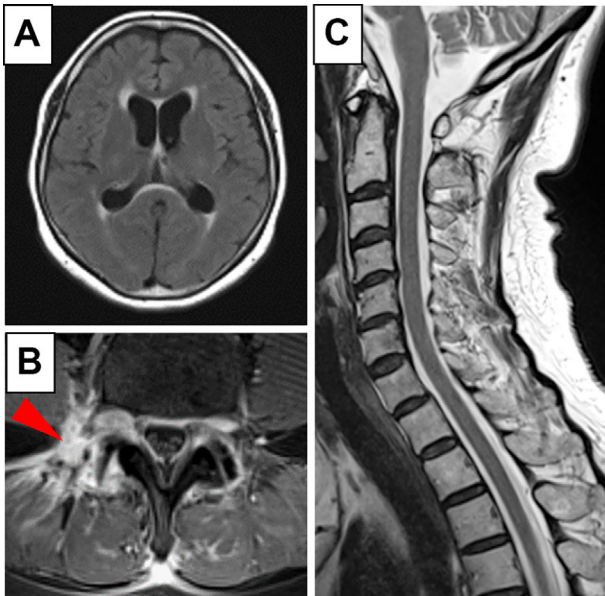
Magnetic resonance imaging, also showing cerebral periventricular hyperintensity on a fluid attenuated inversion recovery image (A), and abnormal lumbar nerve root gadolinium enhancement (B, arrowhead), while intramedullary spinal lesion was not found (C).
